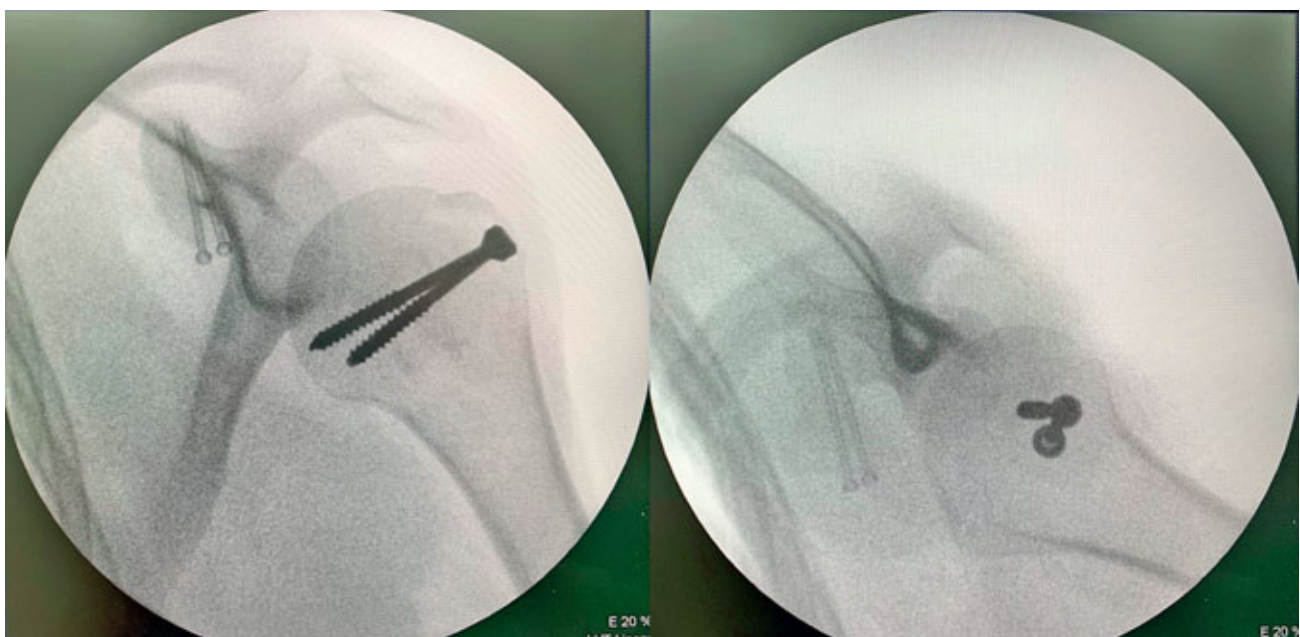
Intraoperative X-ray and fixation of coracoid process fragment with two 3.0 mm lag screws and the fragment of the tuberculum majus with two 3.5 mm lag screws.
